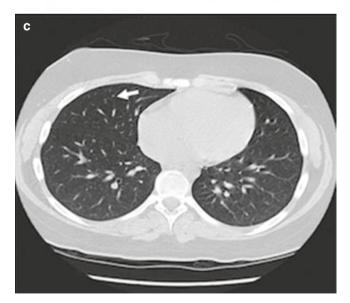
Imaging with [1231]NaI or low-dose [1311]NaI provides a highly sensitive and specific way to detect the metastatic spread of thyroid cancer to sites of disease outside of the neck. In this case, anterior (a) and posterior (b) planar whole-body images taken 7 days after a therapeutic dose of [131I] NaI demonstrate regional lymph node metastases in the neck (*solid arrow*) and distant metastatic spread to the small nodules in the lung bases (*dashed arrows*). Lung metastases were not as easily seen by CT (c, arrow indicates a single small nodule) but were readily apparent in the radioiodine images
